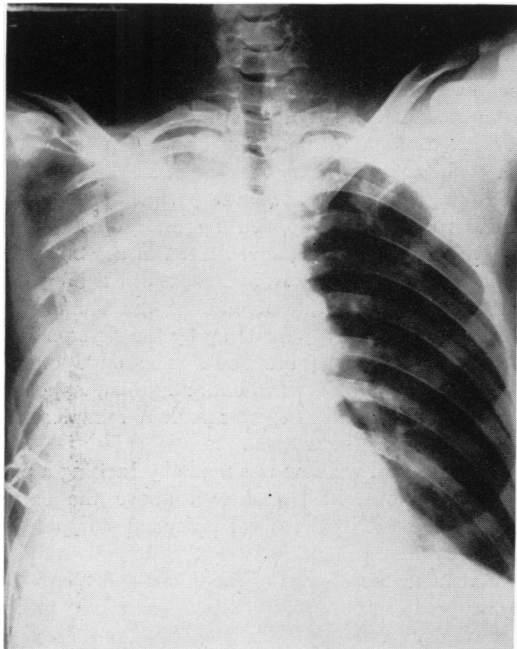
Roentgenogram on admission showing opacity of the right chest and rib fractures as described in the text.
